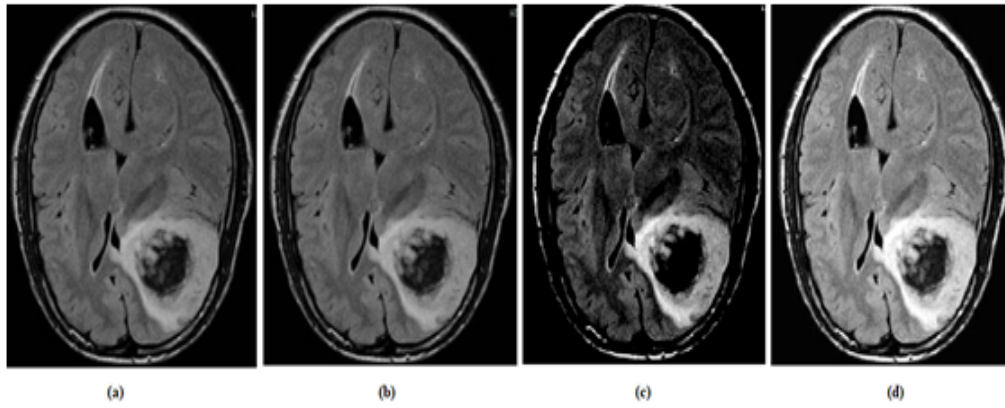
Input MRI Brain Image, (b) Noise Removal Image, (c) Segmented Image, (d) Optimal Threshold Tumor image
